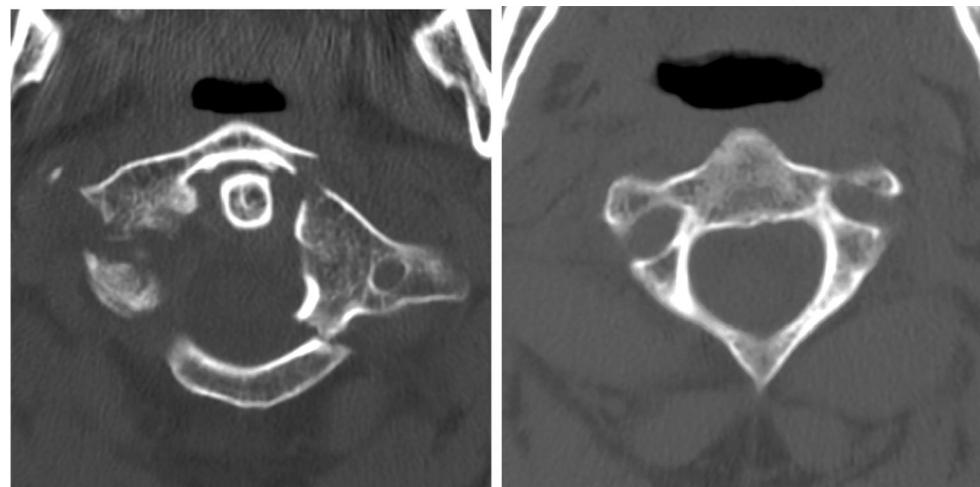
Case 1: pre-operative CT scan of the cervical spine. *Left* multisplintered fracture of the C1 vertebra. *Right* thinning pedicle, arc, and pars articularis of the C2 vertebra as well as bilateral thinning of the anterior lip of the C2 lateral mass. *CT* computed tomography
